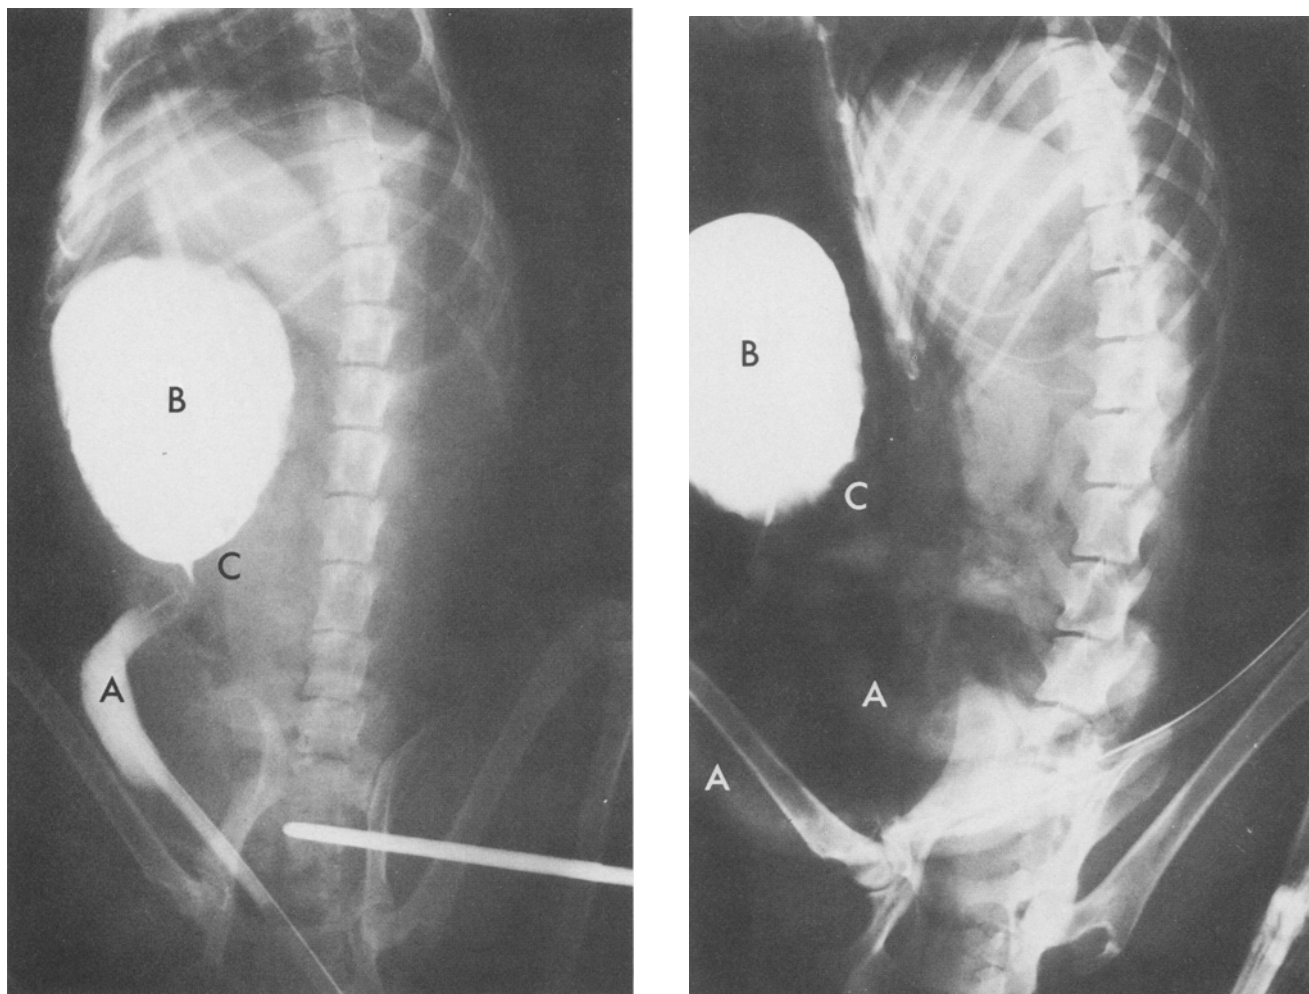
Radiographs of the new continent ileostomy. Afferent limb (A), intestinal reservoir (B), area of outlet valve without extravasation of contrast (C).
